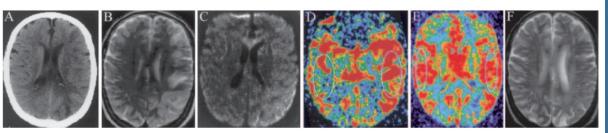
Patient 2. Nonenhanced axial CT, 7 hours after the onset of symptoms, shows left frontal, parietal, and occipital hypodensities involving predominantly the white matter, and some involvement of the overlying cortex with sulcal effacement (A). A few hours later, axial T2-weighted MR images demonstrate diffuse edema of the left hemisphere (B). On axial DW images at the same level, these regions are isointense to slightly hyperintense, consistent with the absence of acute brain ischemia. The slight diffuse DWI hyperintensity is most probably caused by the T2 component of DW images, known as the T2 shine-through effect. (C). PWI documents a relative hyperperfusion (RID=44%) of the left hemisphere (D). A repeat PWI 6 days later demonstrates complete resolution of the previous relative interhemispheric difference (E). Two months later, the extensive T2 hyperintensities present in B have resolved (F).
